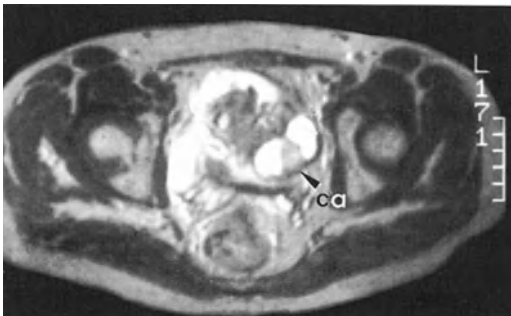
MRI: cystadenoma of left ovary. The T2-weighted image clearly shows a central solid part of the tumor, whereas the liquid parts have a high signal intensity. *ca*, cystadenoma
